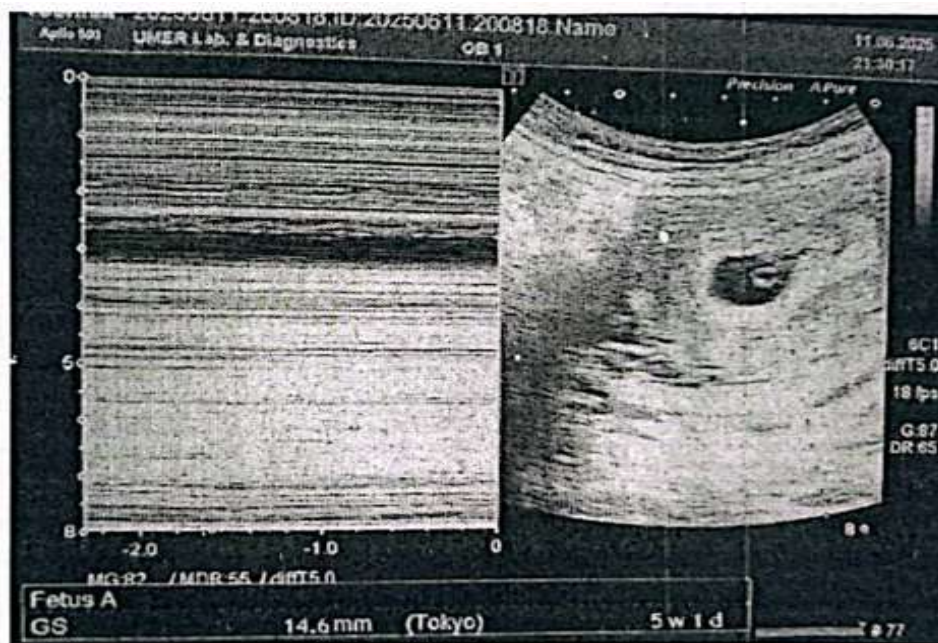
Transabdominal ultrasound scan showing a viable early intrauterine pregnancy. The Bmode image (right) displays a gestational sac with a fetal pole of age 5 weeks 1 day, while the M mode trace (left) confirms fetal cardiac activity with a heart rate. Scan performed on 11 June 2025 using Toshiba Apllo 500 at UMER Lab & Diagnostics.
